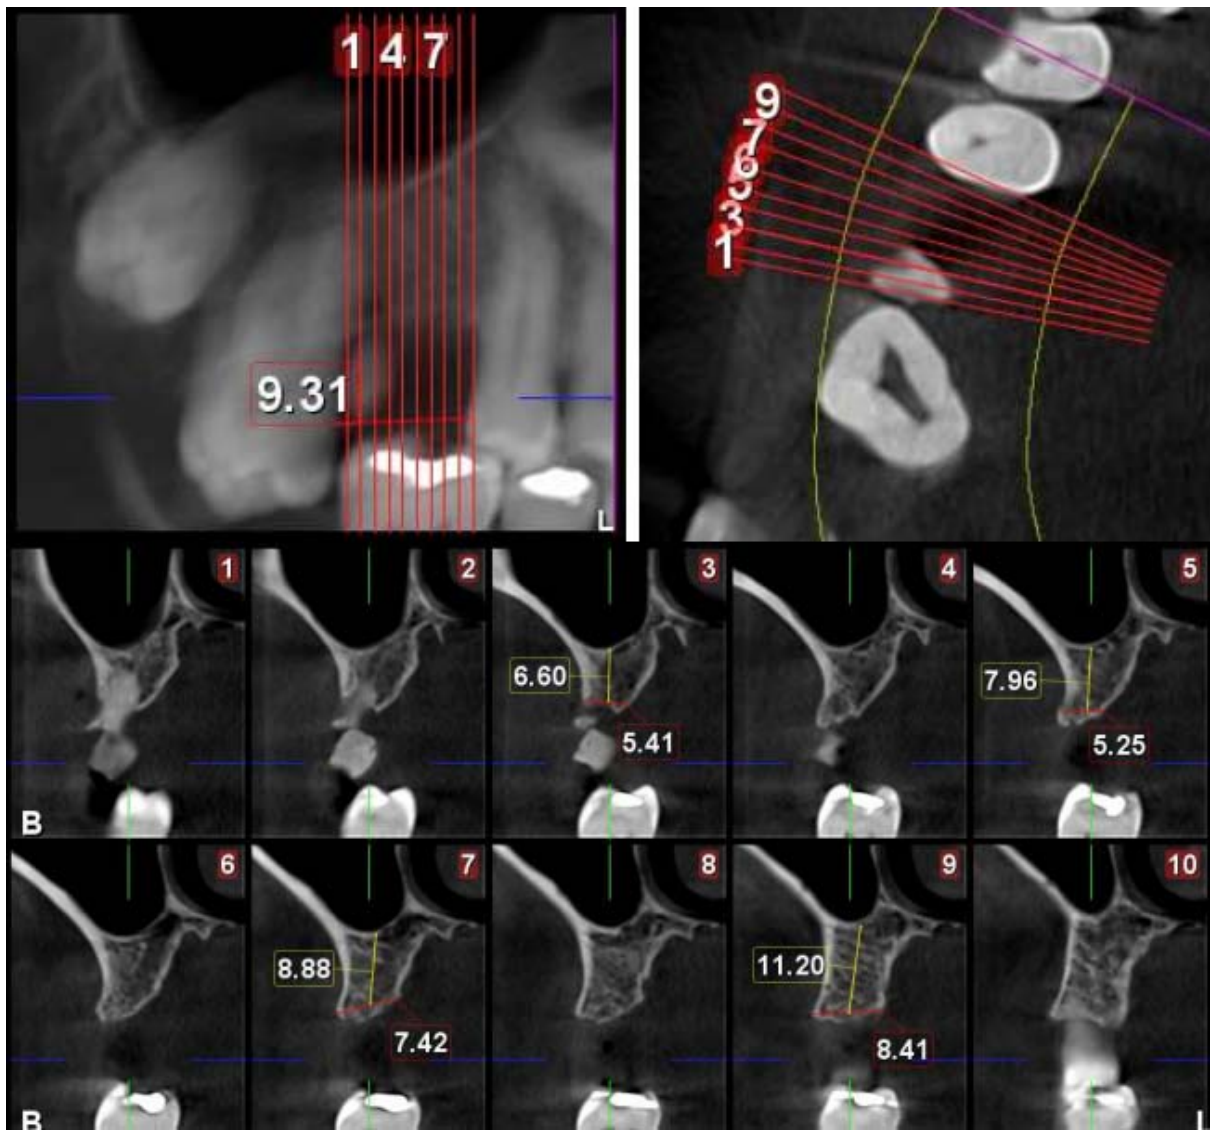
CBCT showing the edentulous site
